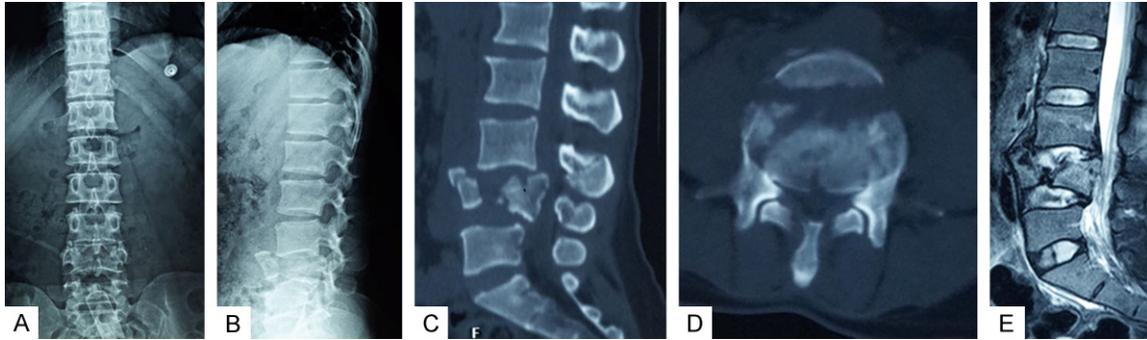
Preoperative X-rays (A, B), mid-sagittal CT images (C), axial CT images (D) and mid-sagittal MRI (E) of the lumbar spine revealed a L4 burst fracture with 60% canal compromise, 50% loss of vertebral body height, a large anteriorly displaced fragment consisting of 50% of the vertebral body depth, and a facet fracture.
